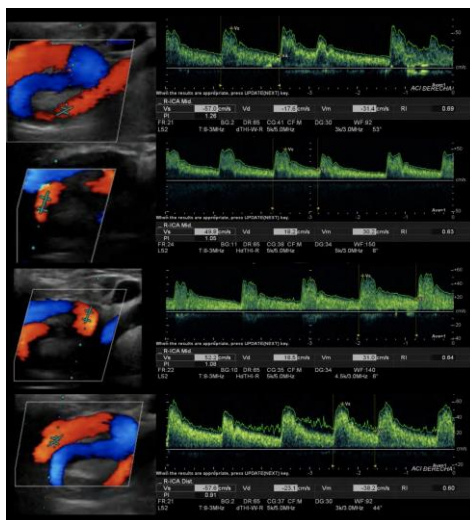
71-years old women with a history of syncope under study. CA with color and pulsed Doppler application. Evaluation in 4 segments of the ICA where PS velocities not greater than 57.6 cm / s are observed, with variability not greater than 8 cm / s.
